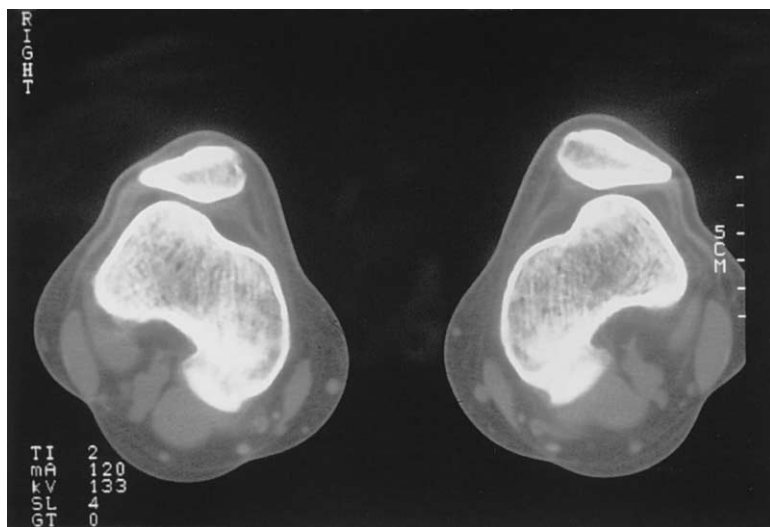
Axial CT scan with lateral patella subluxation causing damage to the retropatellar cartilage and the lateral retinaculum.
